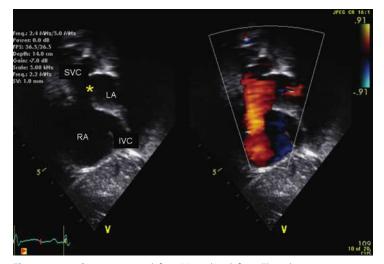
Sinus venosus defect. Note the defect (*) in the posterosuperior portion of the atrial septum, with the superior vena cava (SVC) overriding the defect on the subcostal short axis view (*left*). Color Doppler (*right*) shows left-to-right shunt across the defect. Anomalous drainage of the right upper pulmonary vein is not shown on this view. IVC, inferior vena cava; LA, left atrium; RA, right atrium.
